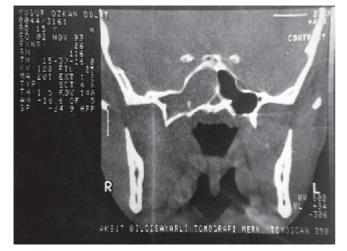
Coronal CT scan of the patient from Figure 4 showing opacity in the sphenoid sinus.
